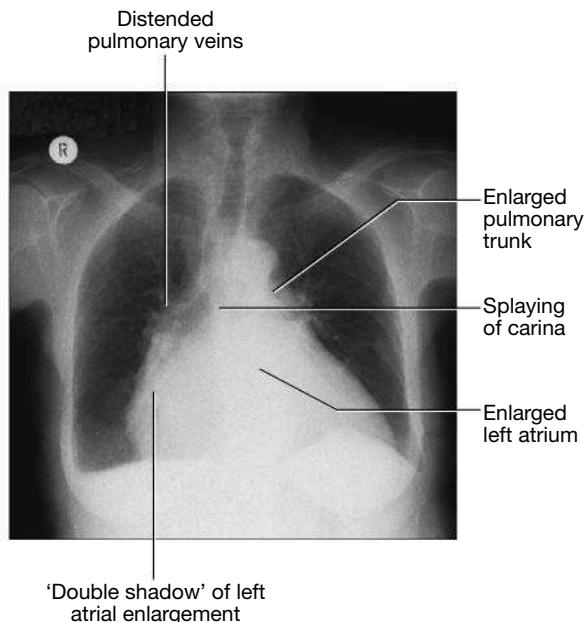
Chest X-ray of a patient with mitral stenosis and regurgitation indicating enlargement of the LA and prominence of the pulmonary artery trunk.
